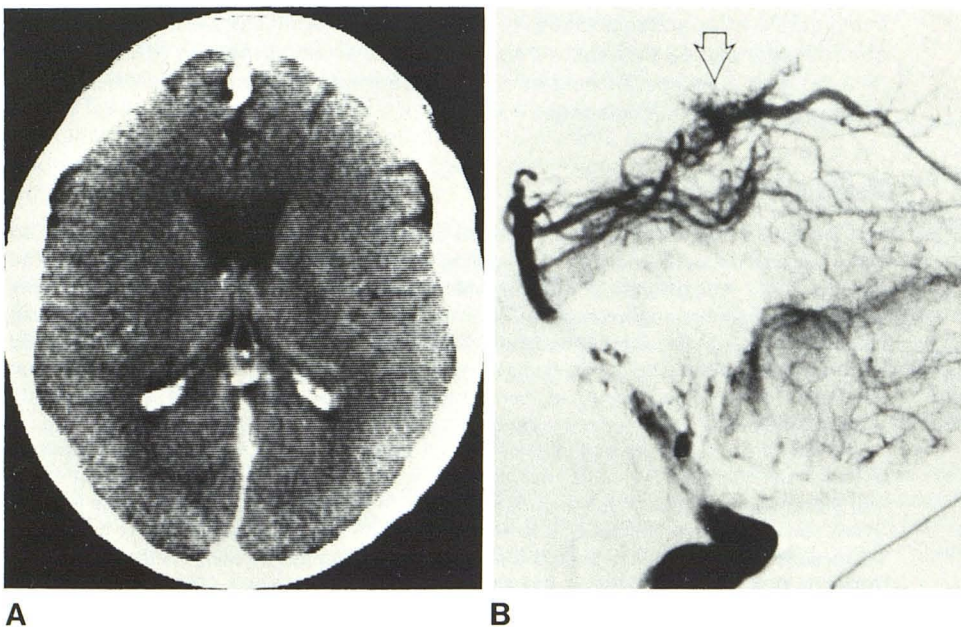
Category 1 lesion. A, Normal immediate contrast CT. Delayed high dose contrast scan (not shown) was normal. B, Lateral vertebral angiogram. Arteriovenous malformation of superior vermis and quadrigeminal cistern.
